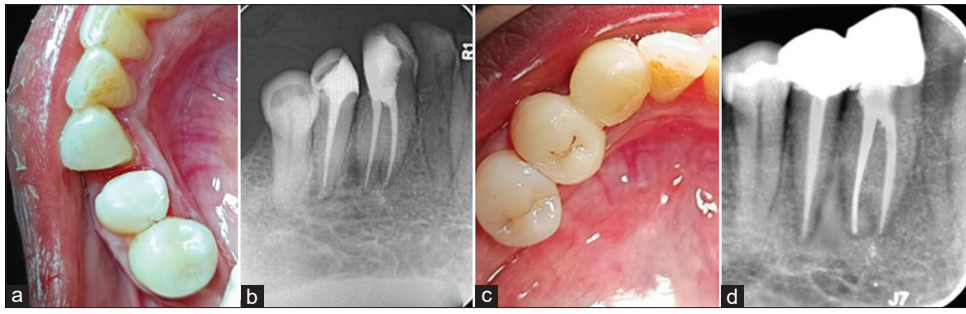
(a) Post-operative intraoral clinical photograph following endodontic treatment of teeth #43 and #44. (b) Post-operative intraoral periapical radiograph showing satisfactory obturation of both canals in tooth #43 and the canal in tooth #44. (c) Post-endodontic restorative phase showing definitive full-coverage restorations placed on teeth #43 and #44. (d) Twelve-month follow-up intraoral periapical radiograph demonstrating resolution of periapical radiolucencies and normal periapical bone trabeculation around teeth #43 and #44
